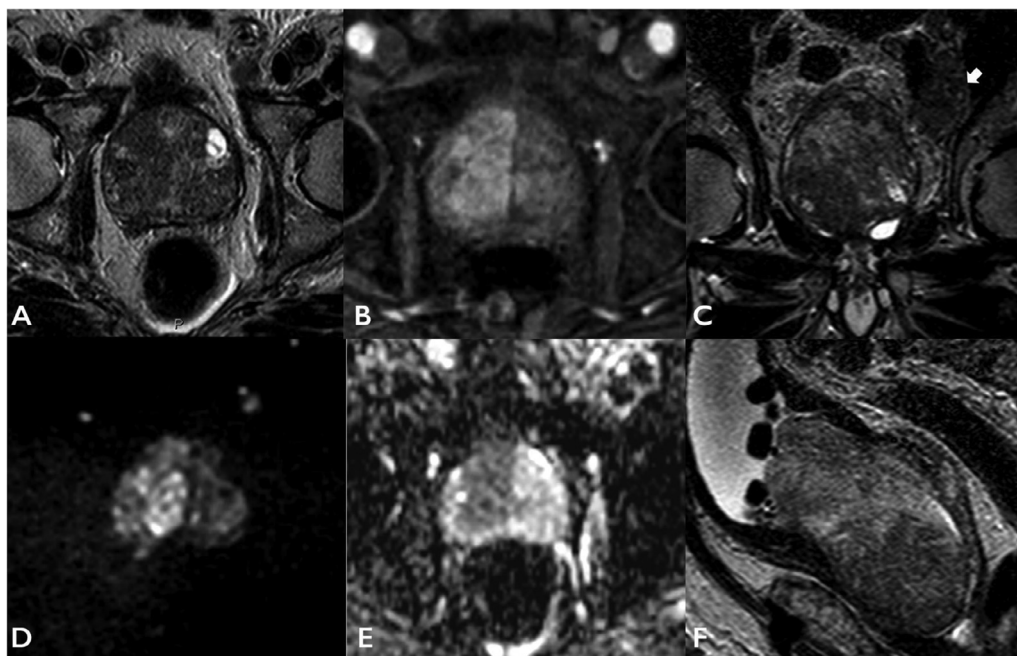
PIRADS 5/5 lesion in the right transitional zone. (A) Axial T2w image of the prostate showing an ill distinct low T2 region in the right TZ. This is also well seen in images C (coronal) and F (sagittal) T2 planes. (B) DCE 2 minutes image showing marked early enhancement of the entire right TZ compared to the left. (C) coronal T2W image showing tumor but also metastatic left pelvic side wall lymph nodes (arrow). (D) B1400 DWI image showing high signal in the right TZ in keeping with restricted diffusion as evidenced by low signal in image E (ADC map).
